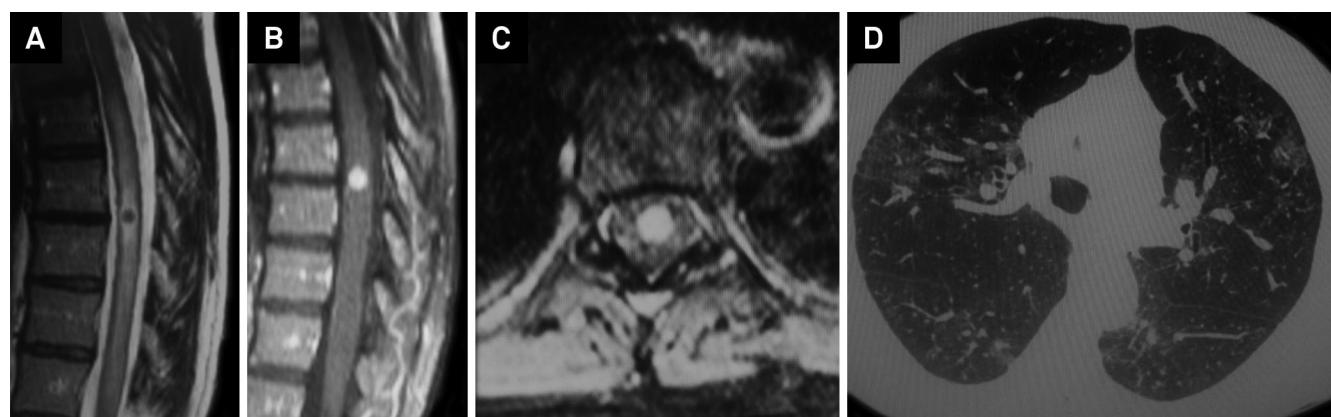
(A) T2-weighted sagittal MRI of the spine revealing an intramedullary lesion at T7 level with nodular enhancement on (B) sagittal and (C) axial post-gadolinium T1-weighted sequences; (D) Chest CT scan disclosing bilateral peripherally located ground-glass opacities and peribronchovascular micronodules.
